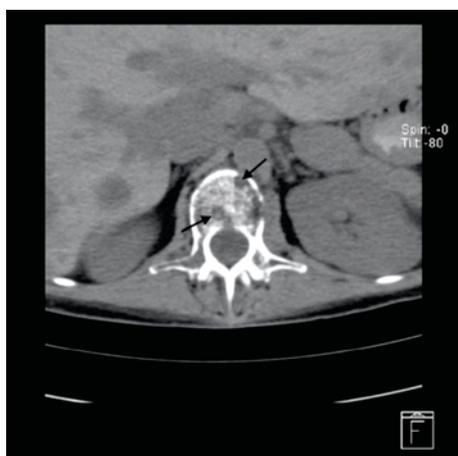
Spinal computed tomography showing diffuse vertebral metastasis (arrow) at D8, D12 and L4.
